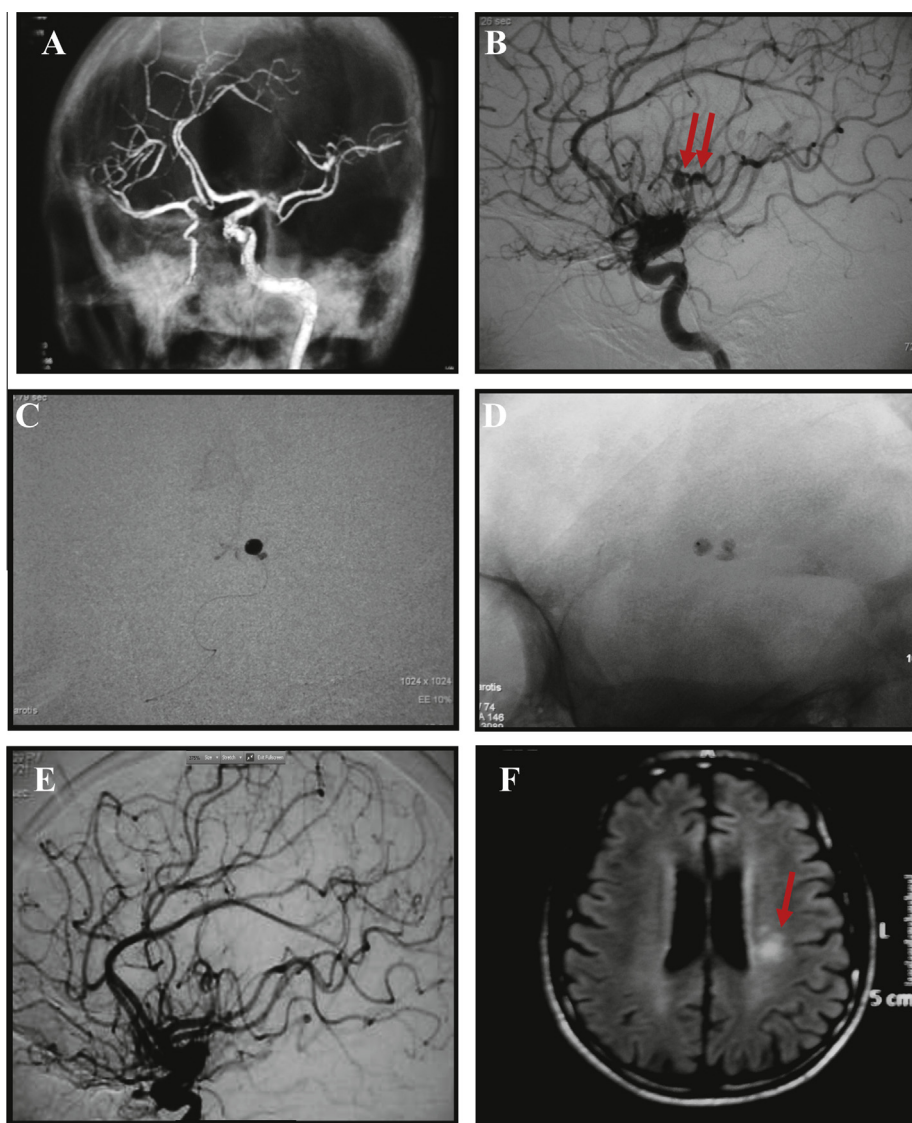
(A) CTA in a clinically free patient showing Lt middle cerebral two distal mycotic aneurysms with occlusion of the Rt internal carotid artery in the neck. (B) Digital subtraction angiogram showing the two aneurysms- arrowed. (C) Microcatheter at the neck of the aneurysm. (D) Occlusion of both by Cyanoacrylate/Lipiodol mixture. (E) Digital subtraction angiogram after treatment. (F) MRI FLAIR post-treatment showing small clinically silent ischemic focus (arrowed).
